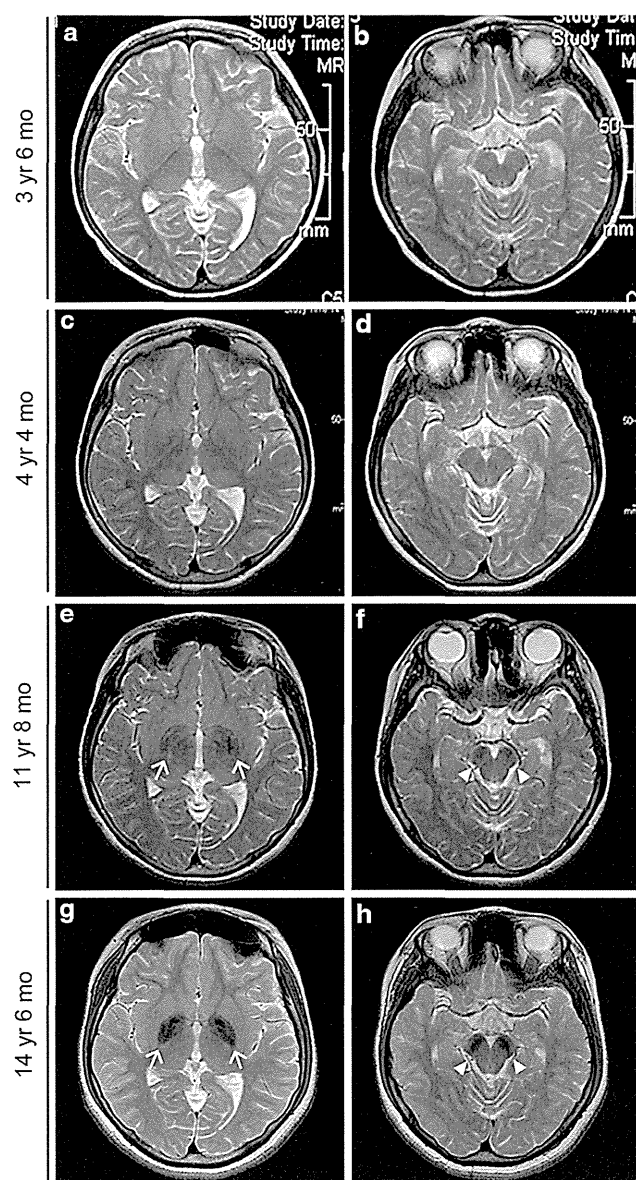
T2-weighted axial images of the patient with a *WDR45* mutation. (a–h) T2-weighted axial images of the patient. ((a, b) at 3 years and 6 months; (c, d) at 4 years and 4 months; (e, f) at 11 years and 8 months; (g, h) at 14 years and 6 months) Brain magnetic resonance imaging (MRI) at 3 and 4 years revealed no remarkable findings in the brain structure, volume and signal intensity (a–d). Mild T2 hypointensity in the globus pallidus (e, arrow) and the substantia nigra (f, arrowhead) was noticed at 11 years of age. At 14 years, T2WI showed strong hypointensity in the globus pallidus (g, arrow) and the substantia nigra (h, arrowhead). mo, months; yr, years.
